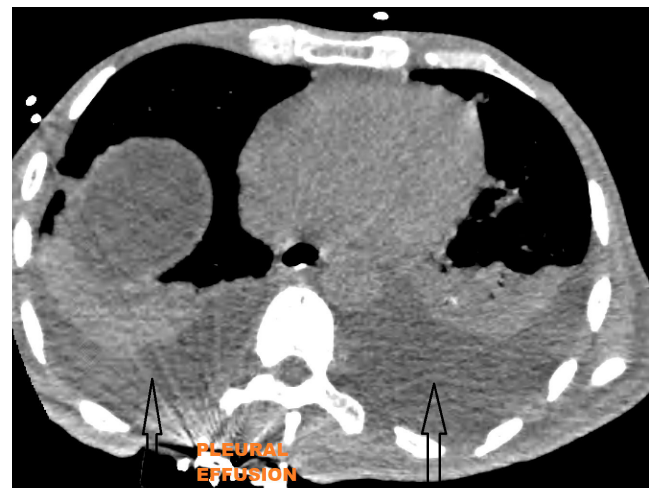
CT- Chest showing areas of consolidation in bilateral upper, right middle, lingula and left lower lobe; bilateral pleural effusion.
